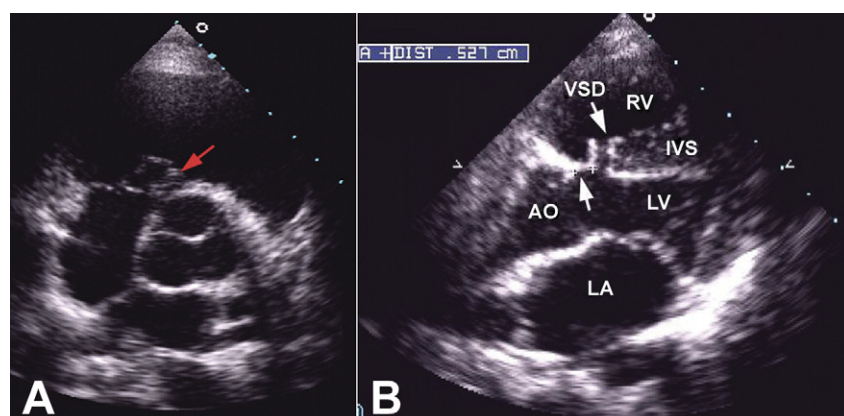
Routine transthoracic echocardiography screening. (A) Presence of abnormal tricuspid main chordae tendineae (red arrow). (B) Distance between the perimembranous ventricular septal defect (VSD) and aortic valve was measured in each patient. (AO = aorta; IVS = interventricular septum; LA = left atrium; LV = left ventricle; RV = right ventricle.)
